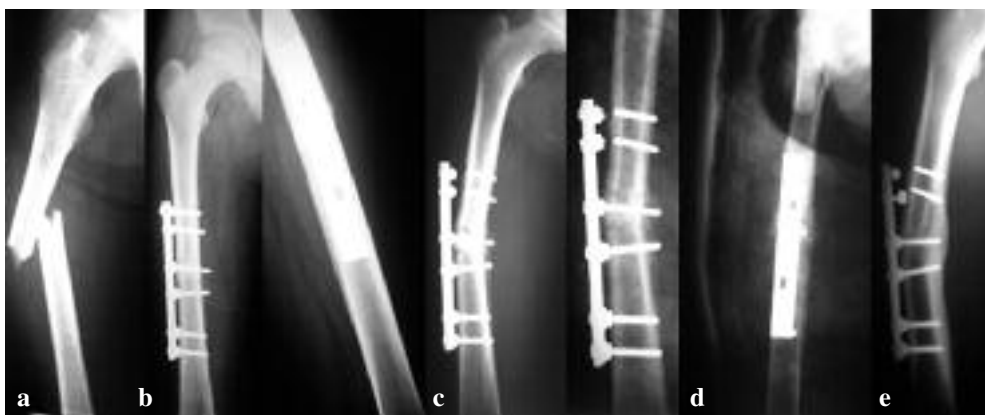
Mid-shaft fracture of the right femur. a : preoperative radiograph ; b : AP and lateral view following fixation with a locked plate ; c : follow-up radiographs showing breakage of the proximal screws with loss of fixation and varus angulation at the fracture site ; d : the limb was immobilised in a spica cast ; e : the fracture healed with fair alignment.
